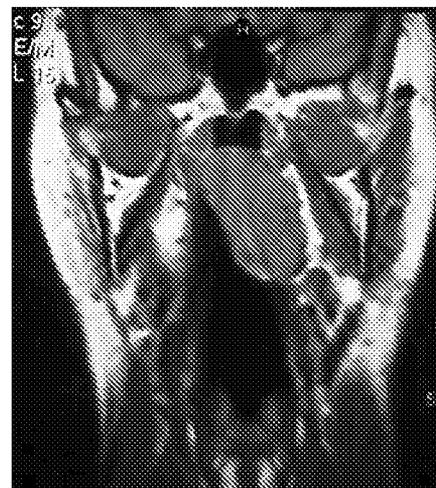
Coronal section T1-weighted MRI scan showing the well-circumscribed tumour arising from the left lateral wall of the nasopharynx.
